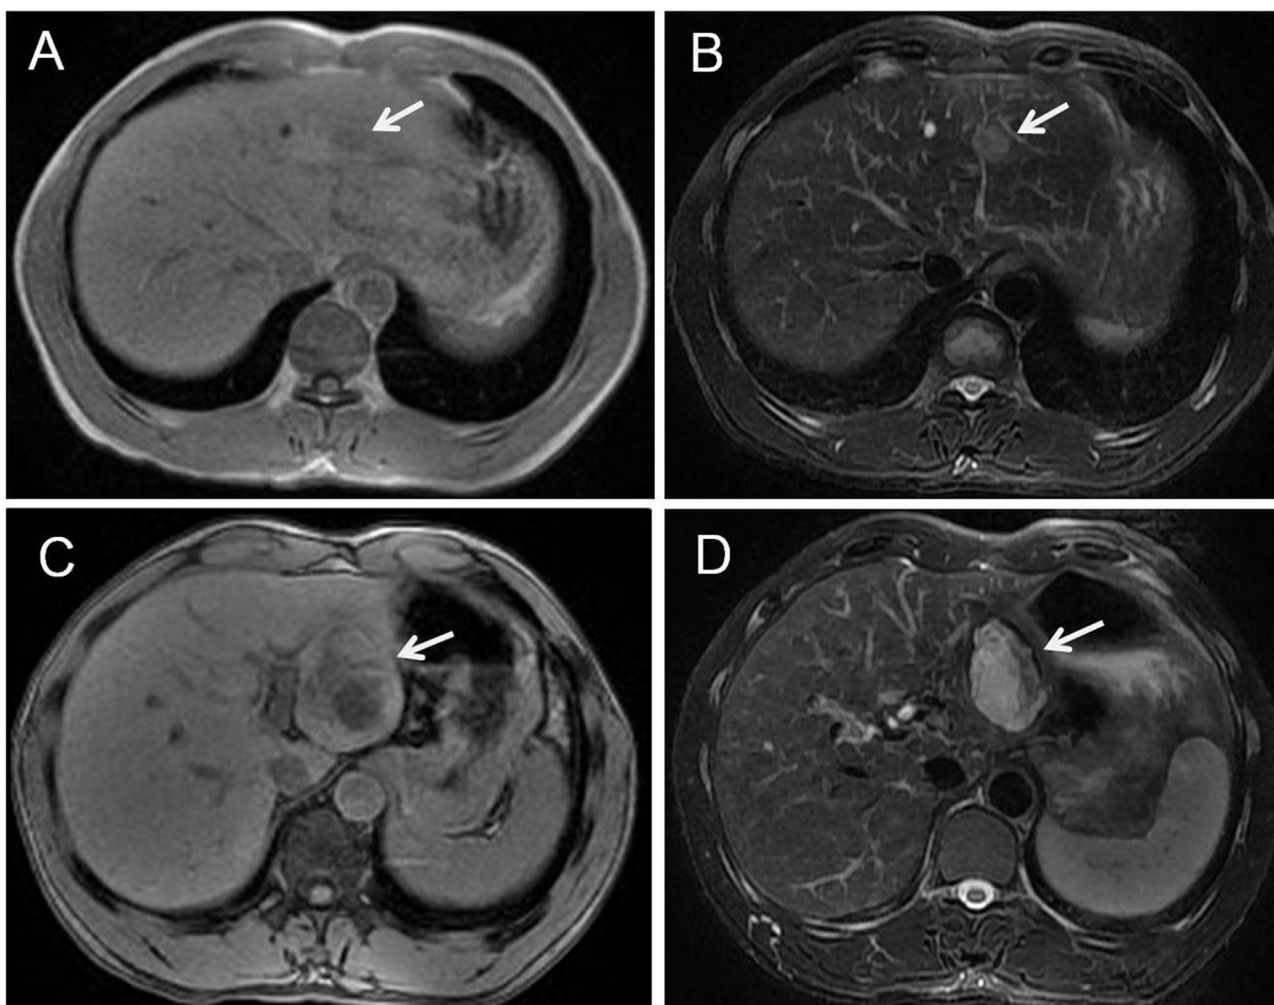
Magnetic resonance imaging: The small lesion in the fourth segment of the liver demonstrates low signal intensity on T1-weighted images (A) and high signal intensity on T2-weighted fat-suppressed images (B). The large lesion in the left lobe of the liver demonstrates low signal intensity on T1-weighted images (C) and largely high signal intensity on T2-weighted fat-suppressed images (D).
